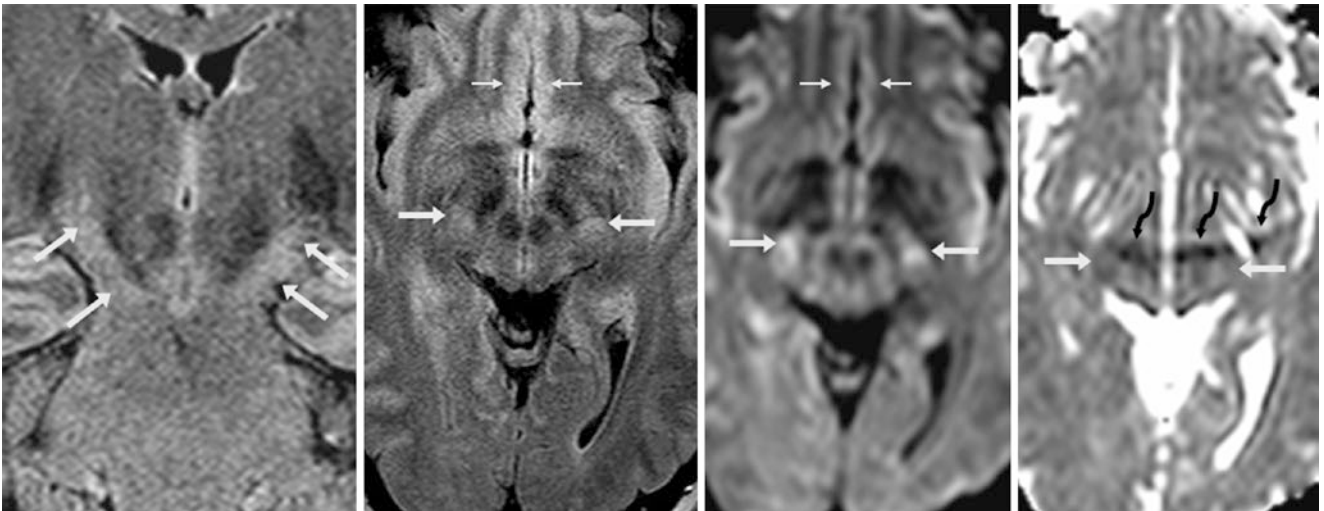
A coronal FLAIR image (*left*) from a 3 T MRI in a 37-year-old shows normal, but quite hyperintense, CSTs (*arrows*) within the cerebral peduncles and subthalamic regions; these are less intense on axial FLAIR (*left middle*) and DWI (*right middle*). Also note the bright
